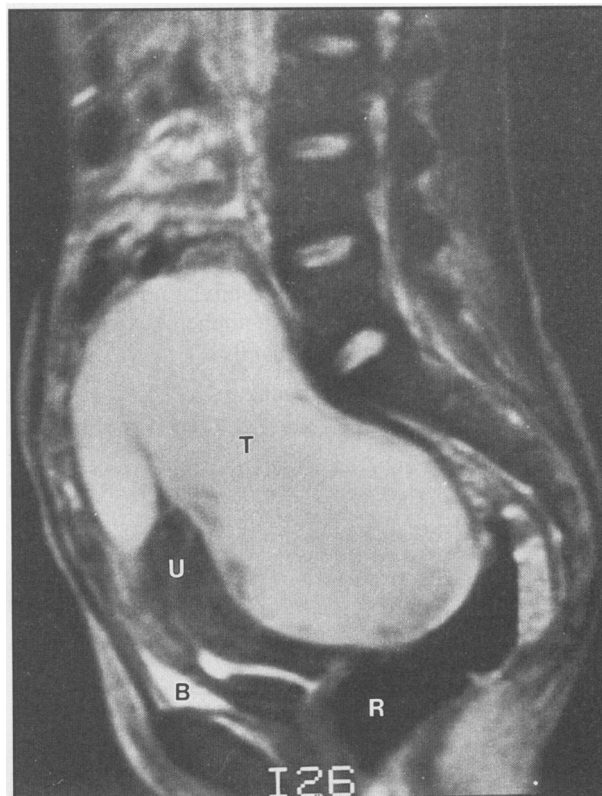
A midline sagittal T2-weighted magnetic resonance imaging scan of the pelvis depicts a tuberculous abscess (T) that appears to originate within the pelvis and extends into the lower abdomen anterior to the uterine fundus (U). R = rectum, B = bladder
